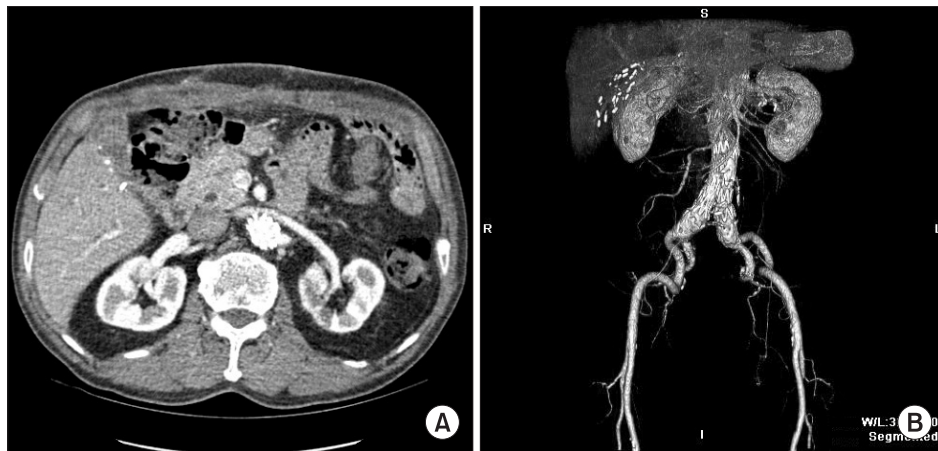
Postoperative contrast enhanced computed tomography scan with 3-dimensional reconstruction showed intact renal artery in axial view (A) and complete aortic stent for abdominal aortic aneurysm (B).
